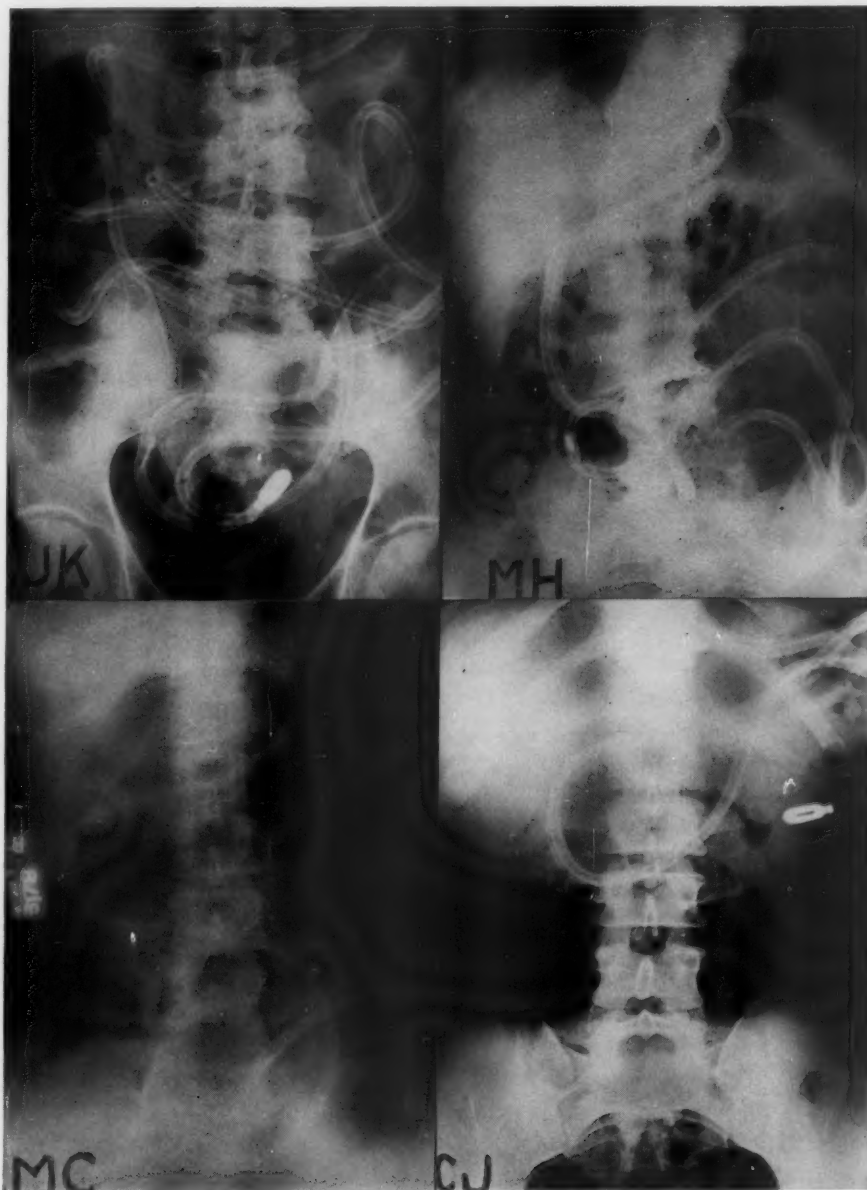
Level of drainage in four cases studied, determined roentgenologically every few days.
